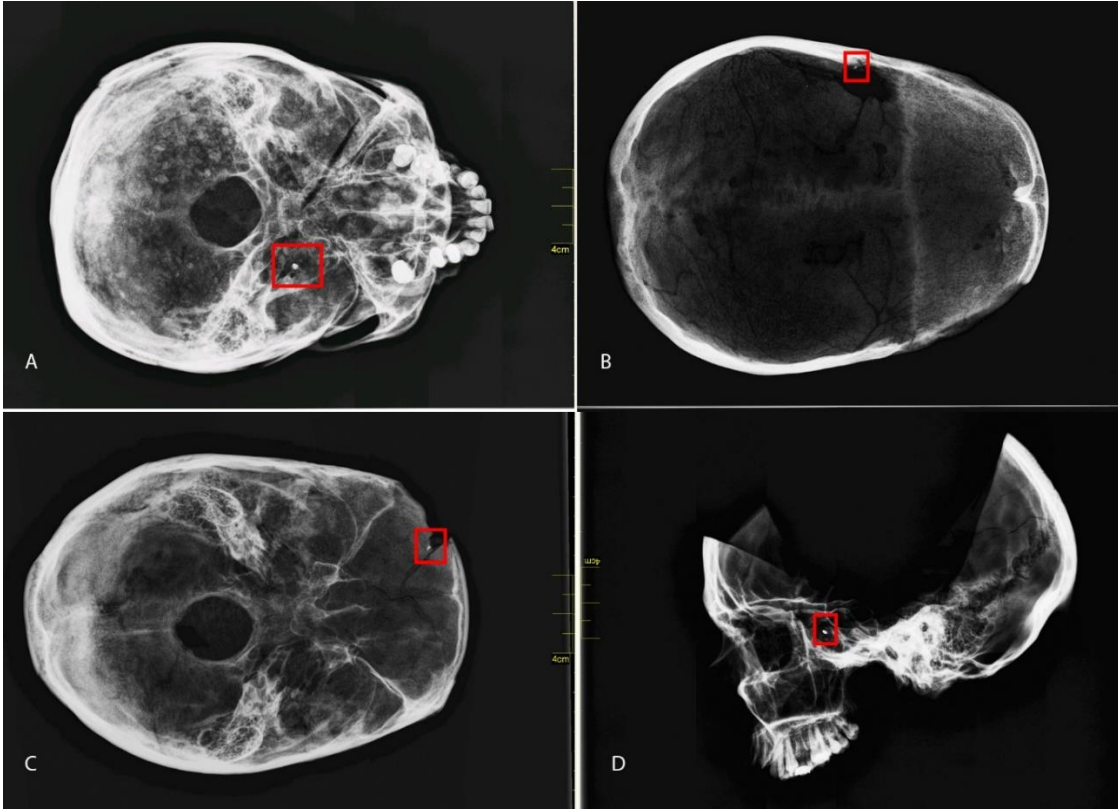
Radiographs for the four crania from separate donors which tested positive for ROM. Image A, a positive ROM detection post-decomposition, then tested negative post-maceration. Images B-D are positive, post-maceration radiographs.
